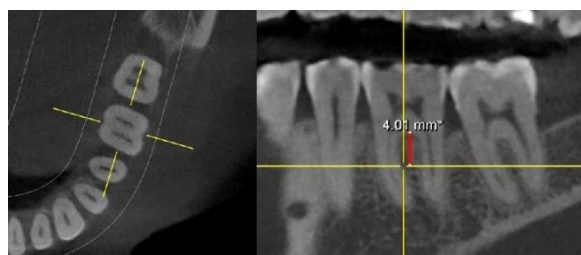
Measurement of dentin thicknesses on CBCT 4 mm below furcation in the axial plane (left) and the sagittal plane (right)
